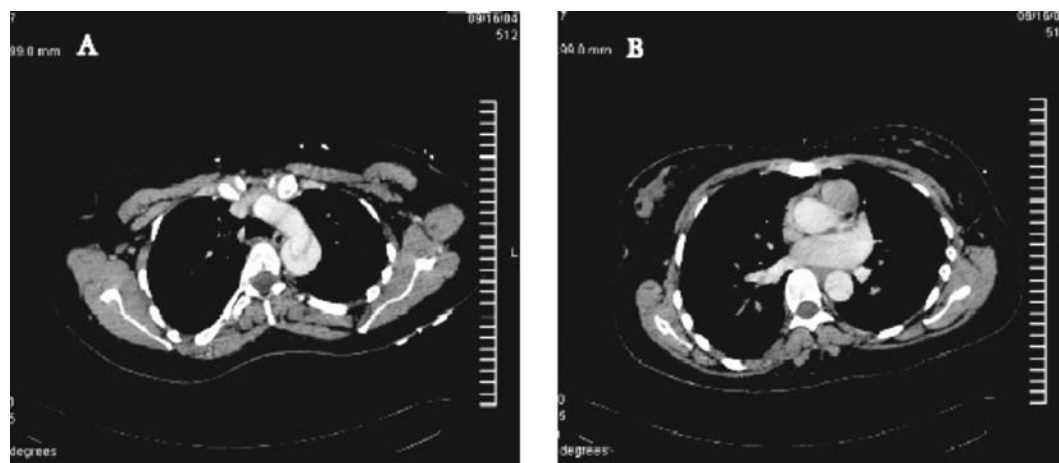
(A&B) Aortic dissection in a patient with Marfan syndrome. From: Ioscovich, A. Images in anesthesia: transesophageal echocardiography during Cesarean section in a Marfan syndrome patient with aortic dissection. *Can. J. Anesth.* 2005; 52: 737–8. (Used with permission of the author and the journal editor.) Figure 3.7A shows the aortic dissection at the level of one section of the descending aorta. Figure 3.7B shows the aortic dissection at the level of the aortic arch. They were both taken at the same time three days prior to the cesarean delivery.
